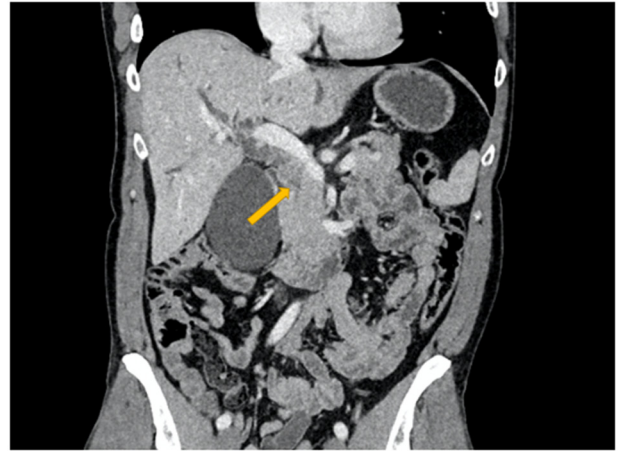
Coronal computed tomography image demonstrating a polypoid intraductal mass within the mid common bile duct (yellow arrow) with associated upstream biliary dilatation.
